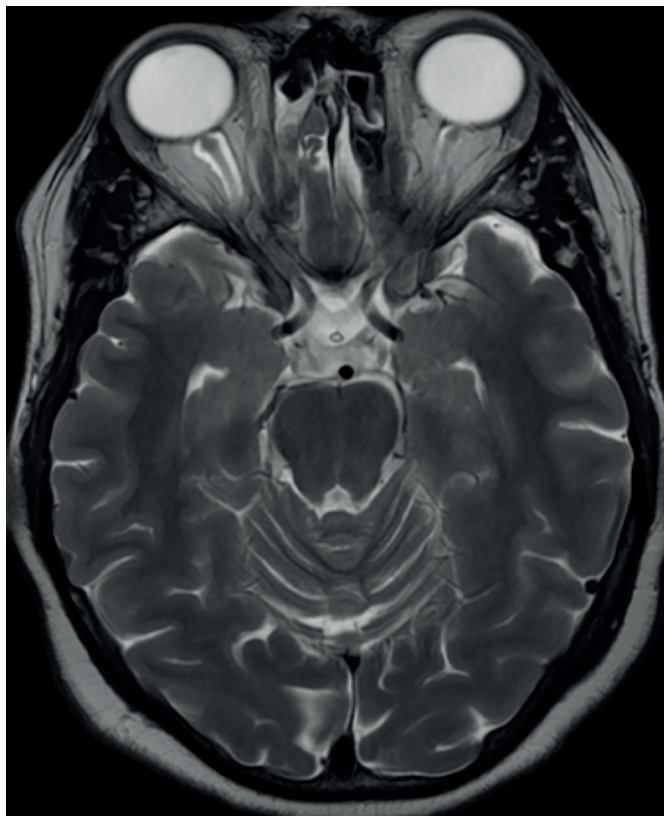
Axial T2W MRI showing bilateral dilated perioptic CSF space (arrow).
